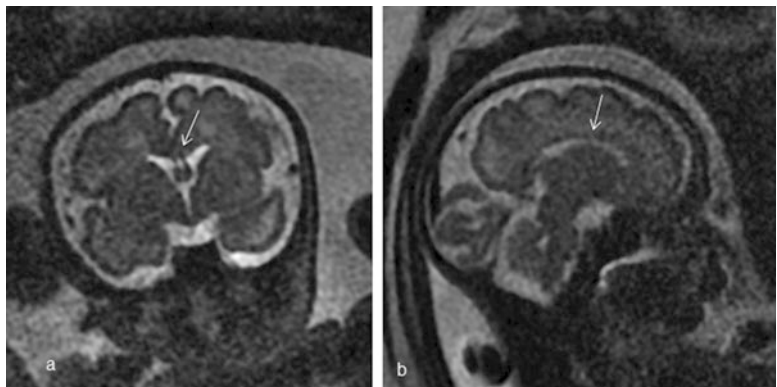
30 week GA fetus. (a) Coronal T2 weighted MRI. (b) Sagittal T2 weighted MRI. *Arrows* indicate normal corpus callosum
